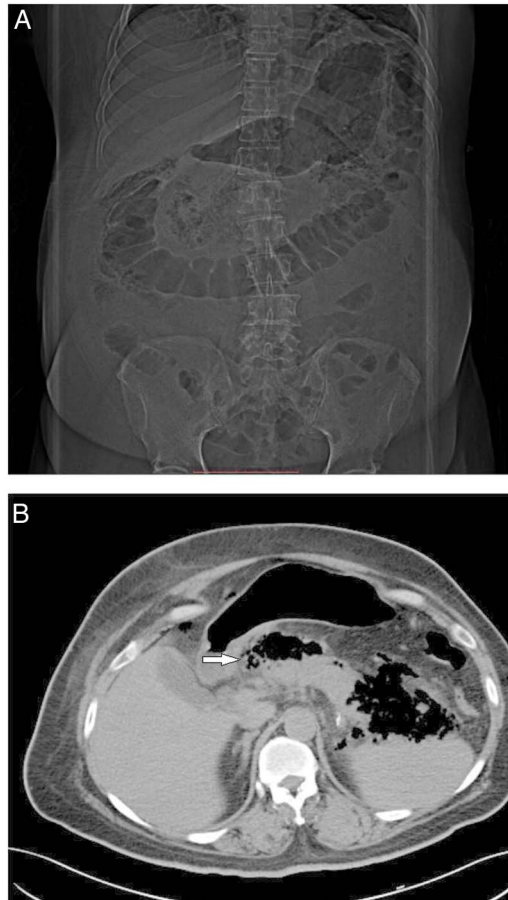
(A) CT image showing the presence of air lucencies in the epigastric region at the level of L1–L2 vertebral bodies, likely emphysematous pancreatitis. (B) Axial non-enhanced CT of the abdomen at the level of pancreas showing intraparenchymal air foci in the region of pancreatic head, body and tail (arrow) extending into the lesser sac and adjacent retroperitoneal space.
